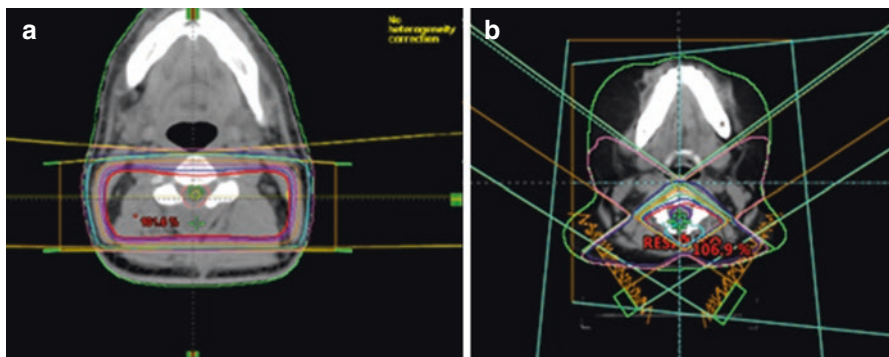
Axial images of planning CT showing field projections and isodose lines for lateral opposed (a) and posterior oblique (b) field techniques
